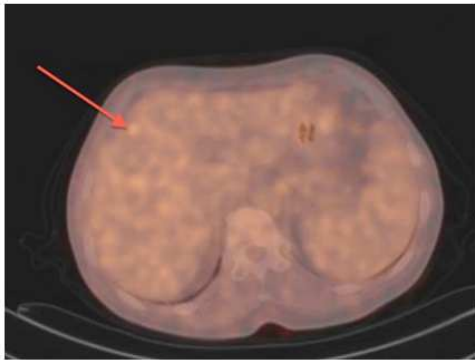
Preoperative PET-CT scan shows segment 2-4a metastases in the liver (Red arrow shows metastasis).
